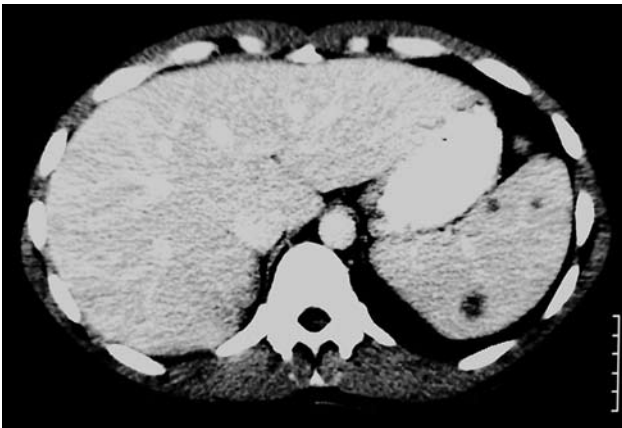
Computed tomography of the abdomen demonstrating several discrete low attenuation foci within the mildly enlarged spleen. Liver and other internal organs were free of findings and no enlarged lymph nodes were noted.
